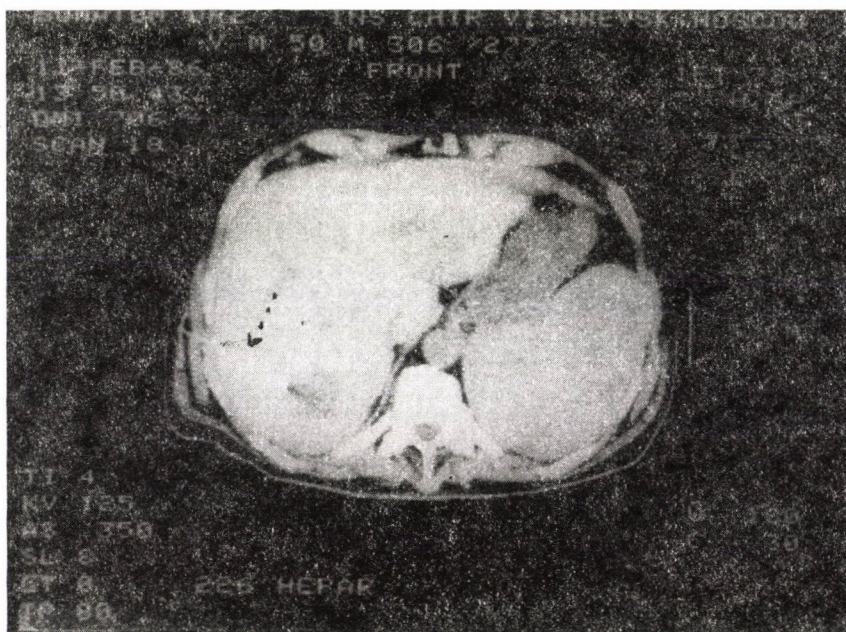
Control CT scan eleven days later. The residual abscess was solved by puncture
